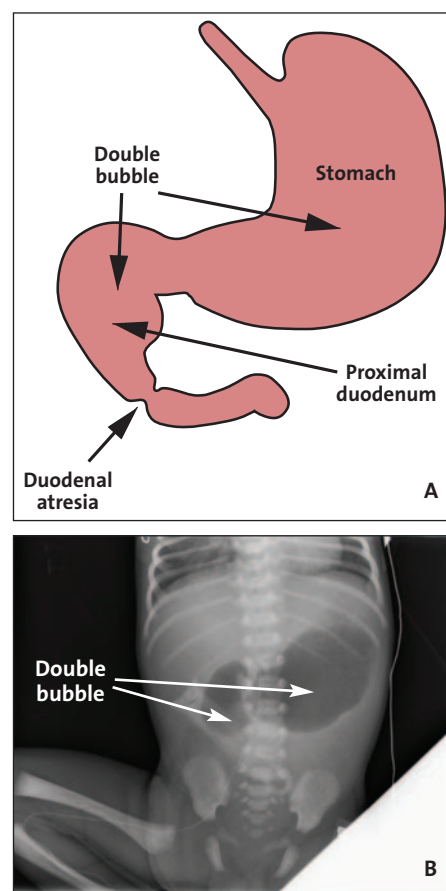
(A) Duodenal atresia and the double bubble. (B) A plain X-ray of a two-day-old infant born at 36 weeks' gestation showing the double bubble appearance in the upper abdomen with no gas seen distally. The baby had respiratory distress, sepsis and jaundice.
